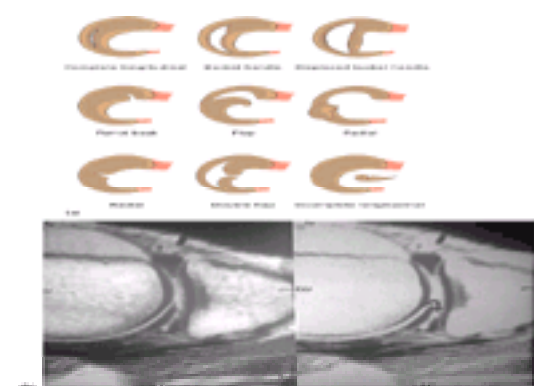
(a) Classification of meniscal tears. (b) MRI of medial meniscal knee tear.
